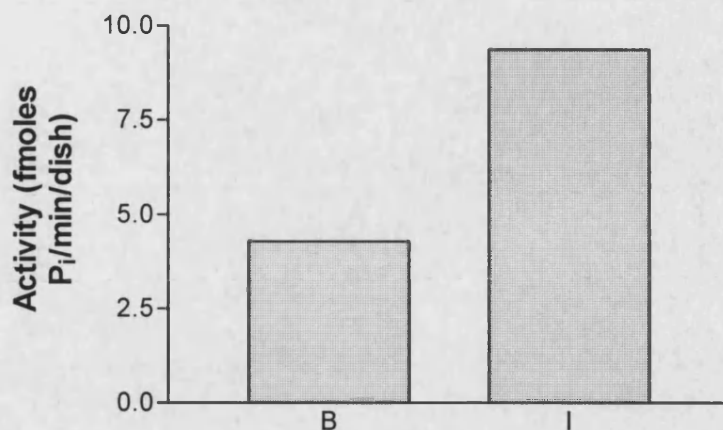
Phosphorylated Protamine Sulphate Binds to Rac-CT Immunoprecipitates.
